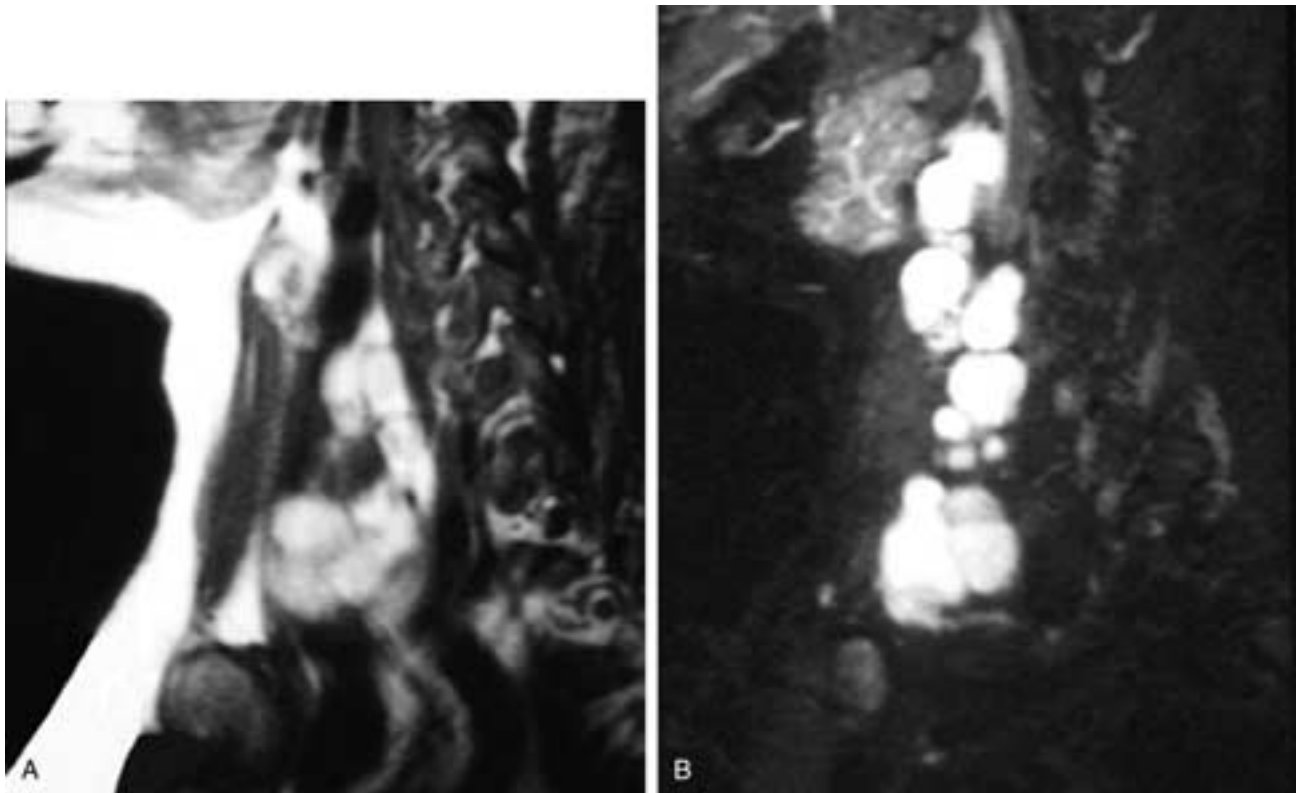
Sagittal T1-weighted (A) and T2-weighted (B) MR images show multiple high signal intensity nodes in levels II to IV. These were all metastatic papillary thyroid carcinoma nodes.
